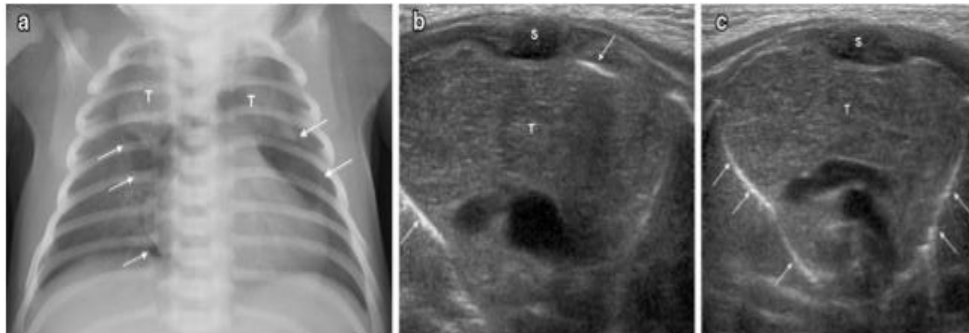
Pneumomediastinum in a 2-day-old boy with dyspnea. Chest radiograph shows abnormal radiolucency along both cardiac junctions (arrows) at thymus elevation. b, c Ultrasonographic scan of the transverse mediastinum showing thick echogenic lines (arrows) along the anterior and lateral borders of the thymus due to pneumomediastinum. Note that the sternum is cartilage, allowing the transmission of sound beams. T thymus, S sternum.^{10,12}
